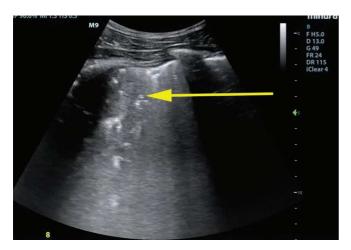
Dynamic air bronchogram (arrow) with B-lines indicative of pneumonia. See Video 5.10. Adapted from Supplemental Video 2 of Le Neindre A, Mongodi S, Philippart F, Bouhemad B. Thoracic ultrasound: Potential new tool for physiotherapists in respiratory management. A narrative review. *J Crit Care.* 2016;31(1):101–109. doi:10.1016/j.jcrc.2015.10.014.
